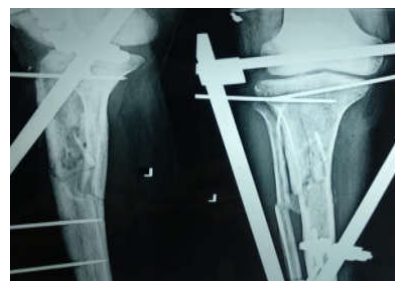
Radiograph Showing fracture union
